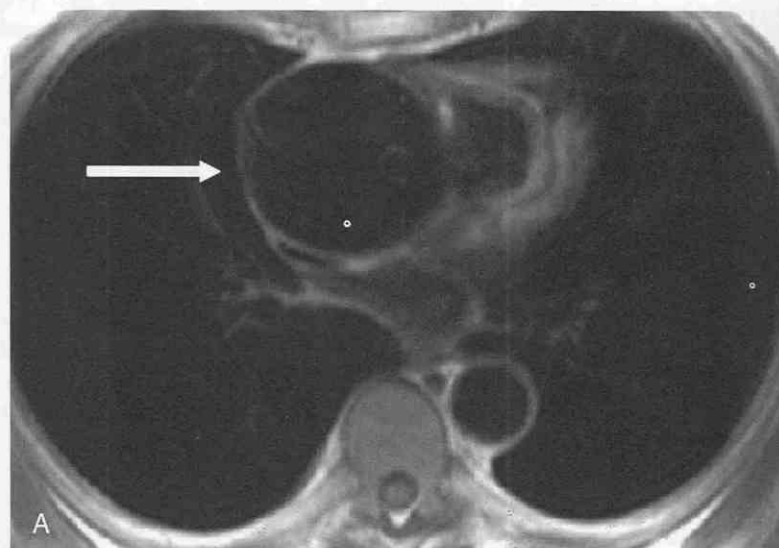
A, Axial T1-weighted MR image shows marked dilatation of the ascending aorta (arrow). B, Sagittal oblique T1-weighted MR image of the thoracic aorta shows dilatation of the ascending aorta with effacement of the sinuses of Valsalva. C, Coronal cine gradient-recalled echo MR image of the ascending aorta shows dilatation of the ascending aorta without significant valvular insufficiency.
